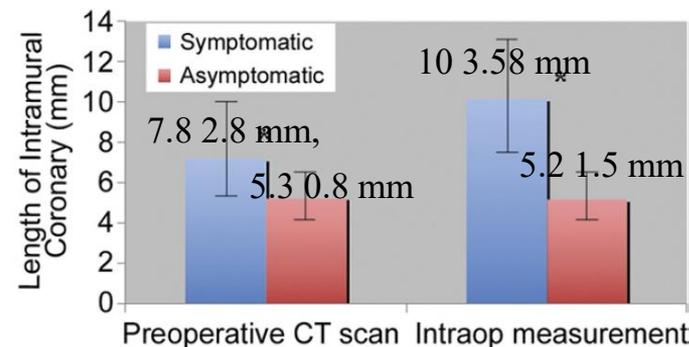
Data are shown for the length of intramural coronary artery in patients with (blue) and without (red) symptoms. A greater intramural coronary length measured by preoperative imaging (computed tomography or magnetic resonance imaging) or by direct intraoperative measurement correlated with preoperative symptoms. The error bars show the standard deviation. * $p < .001$. (CT = computed tomography.)
